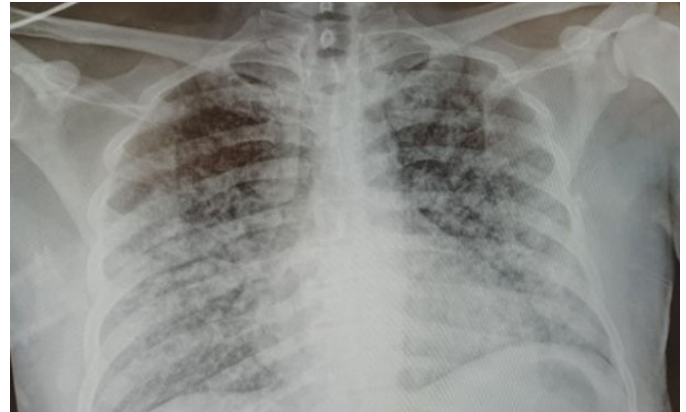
Chest radiograph: anteroposterior view with bilateral nodular radiopacities.
